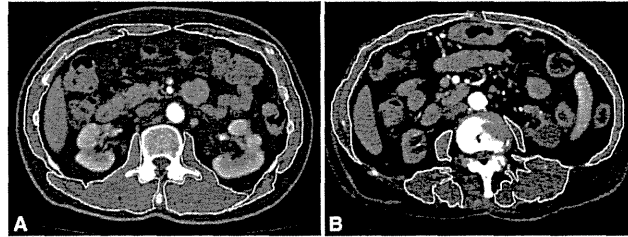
Representative transverse computed tomography (CT) images are shown of (A) a patient without sarcopenia and (B) a patient with sarcopenia. The images were taken at the third lumbar vertebra. The white outline shows the calculated skeletal muscle area.
